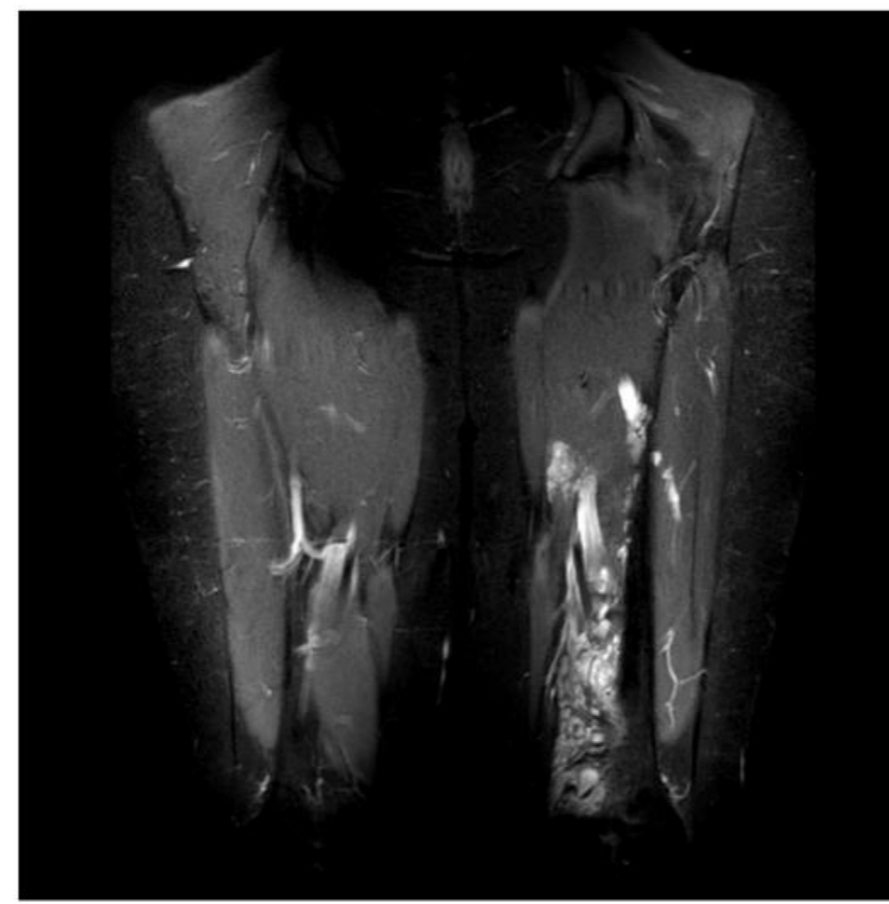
MRI with contrast, end of month one treatment.
